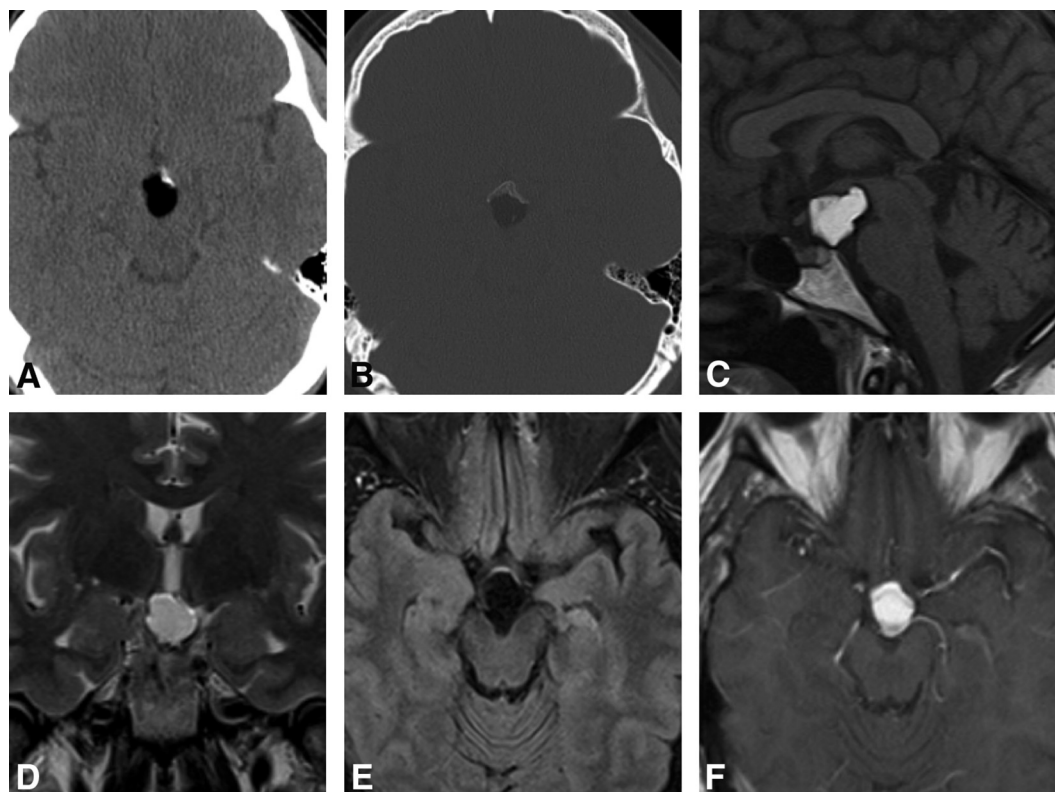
Dermoid cyst. Axial soft-tissue (A) and bone (B) algorithm CT reconstructions; sagittal T1-weighted (C), coronal T2-weighted (D), axial fat-suppressed T2W FLAIR (E), and postgadolinium T1-weighted (F) images of a dermoid cyst. A 35-year-old patient with an incidental finding of a pituitary infundibular lesion on a CT of the head performed for trauma. CT of the head in soft-tissue (A) and bone algorithm (B) reconstructions demonstrates a hypoattenuated midline lesion centered in the suprasellar cistern, with associated anterior calcifications. The lesion demonstrates fat attenuation. MR imaging of the brain was then obtained, which demonstrated the lesion to be centered in the suprasellar cistern along the infundibulum and demonstrated hyperintense signal intensity on T1WI (C) and T2WI (D), hypointense signal intensity on fat-suppressed T2 FLAIR (E), and no contrast enhancement after gadolinium administration (F). Note the chemical shift artifact along the frequency-encoded direction.
